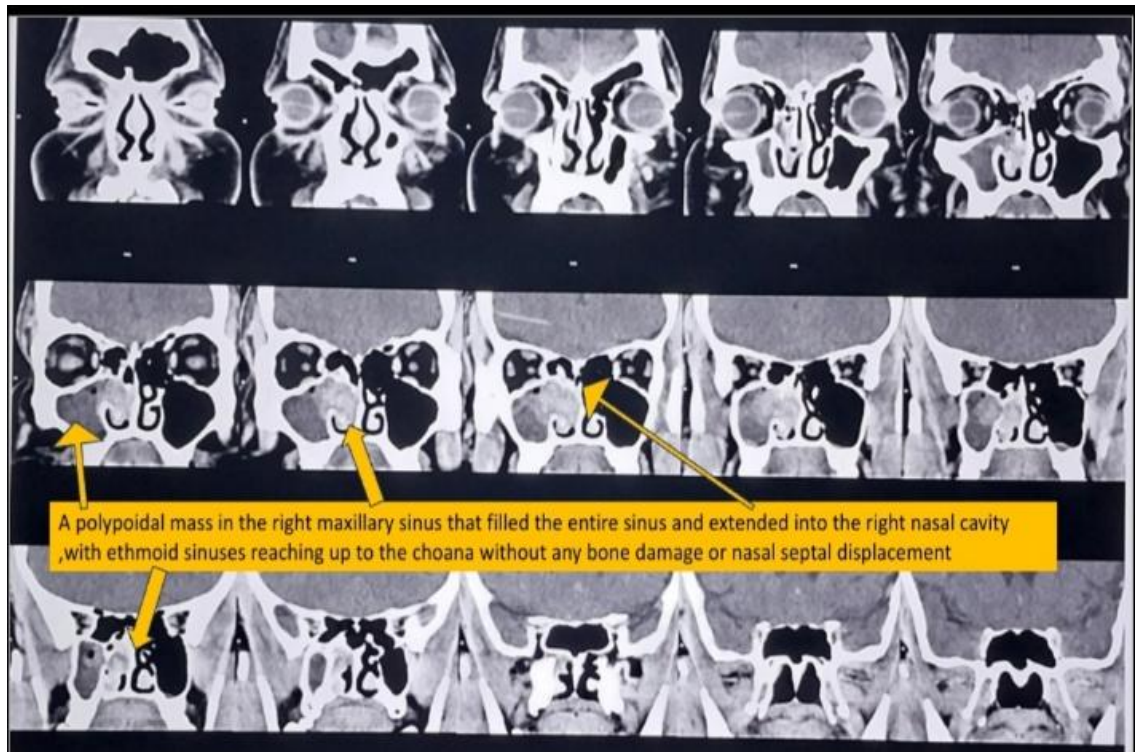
Contrast enhanced CT scan of PNS-coronal section showing extent of Sinonasal mass filling the entire right maxillary sinus, the right nasal cavity, with ethmoid sinuses reaching up to the choana without any bone damage or nasal septal displacement.
